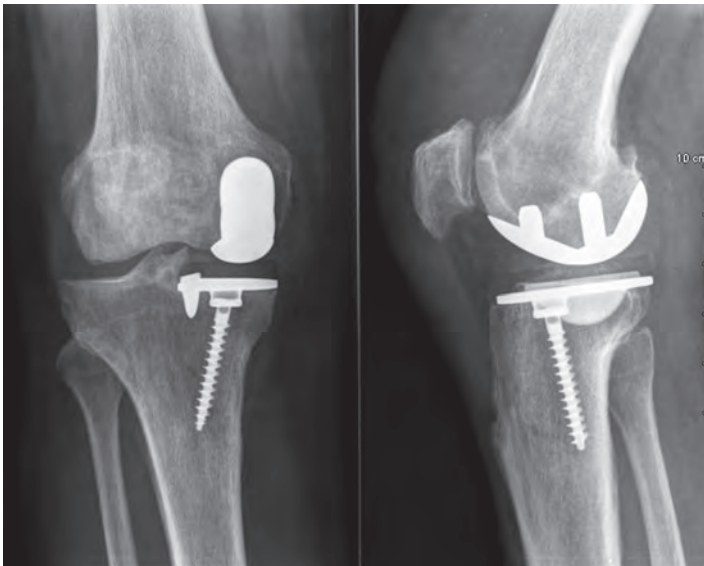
Post-operative X-Ray demonstrating a good realignment and the absence of anterior translation despite a torn ACL. Note that the tibial slope has been kept neutral.
